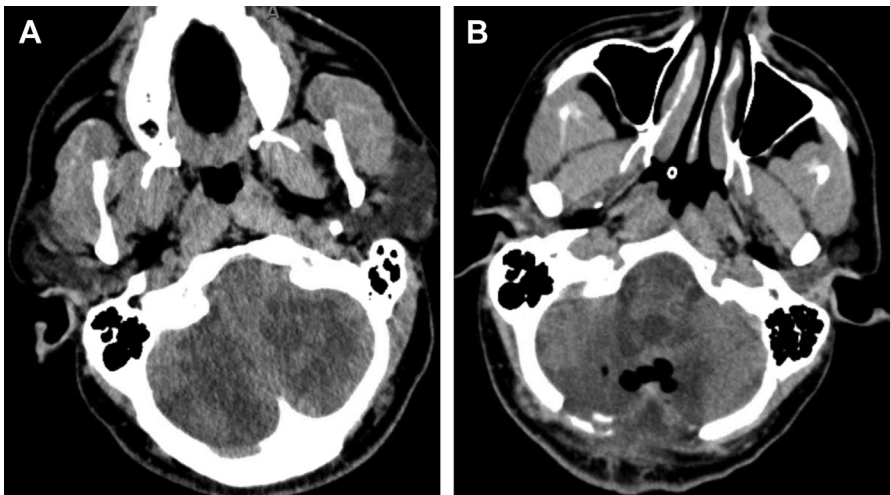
(A) Noncontrast head CT in a patient with bilateral cerebellar infarcts with edema, fourth ventricular compression, and brainstem compression. (B) Noncontrast head CT in the same patient post-suboccipital decompression with a resolution of brainstem compression and ventricular compression. (Courtesy of The University of New Mexico, Albuquerque, NM.)
